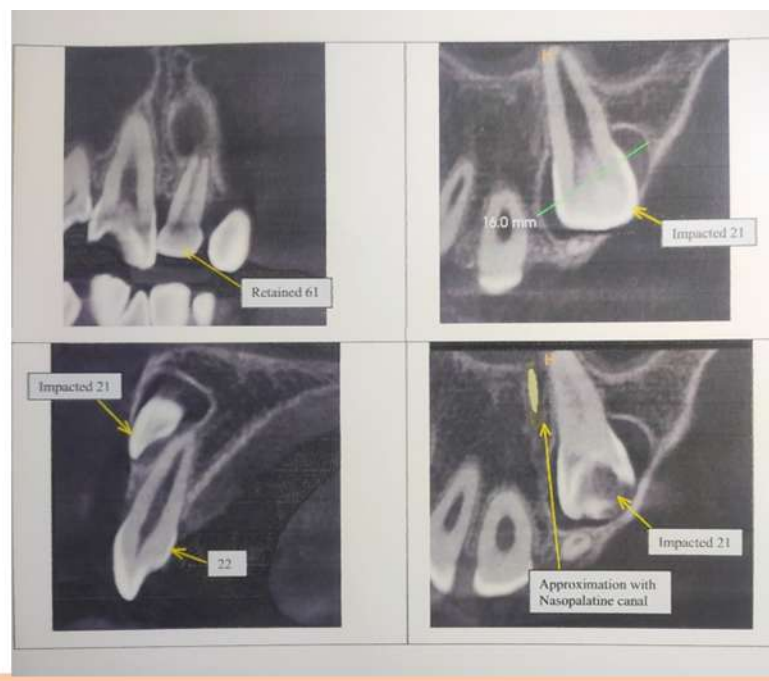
Cone Beam CT Image showing deciduous left Central Incisor and Impacted Left Permanent Central Incisor on Coronal view, Sagittal and Axial view respectively
